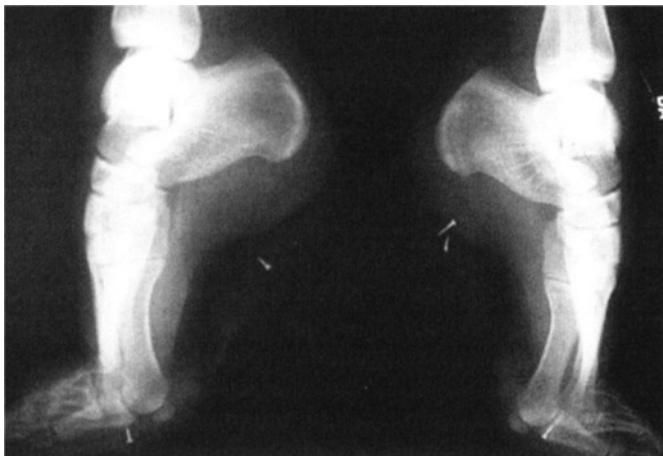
Radiographic evaluation of relevé to demi-pointe. The metatarsophalangeal joints are dorsiflexed and the metatarsals are collinear with the tibia.
